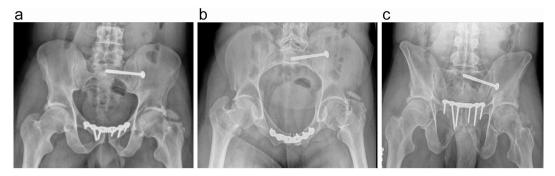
(A) AP, (B) inlet and (C) outlet radiographs of final pelvic ring fixation at 20 months postop.
